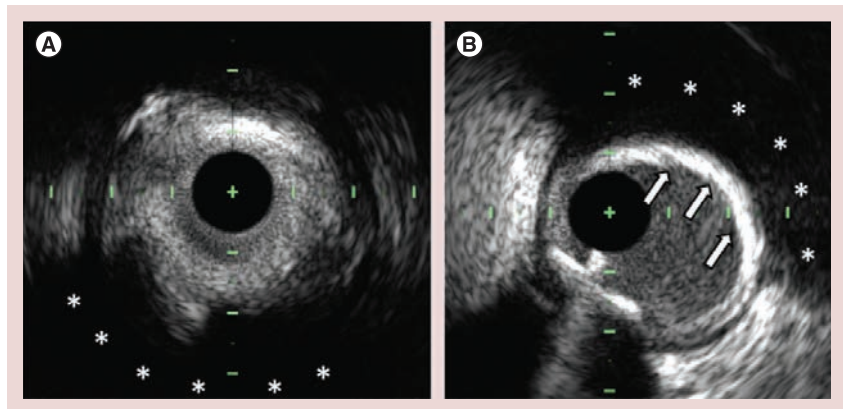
Attenuated plaque by intravascular ultrasound. (A) Attenuated plaque by intravascular ultrasound is shown and is defined by the presence of attenuation of the ultrasound signal (asterisks) in the absence of overlying calcification. (B) Attenuation of the ultrasound signal (asterisks) secondary to calcification (arrows) is shown. Attenuated plaque should not be confused with attenuation secondary to calcification.
